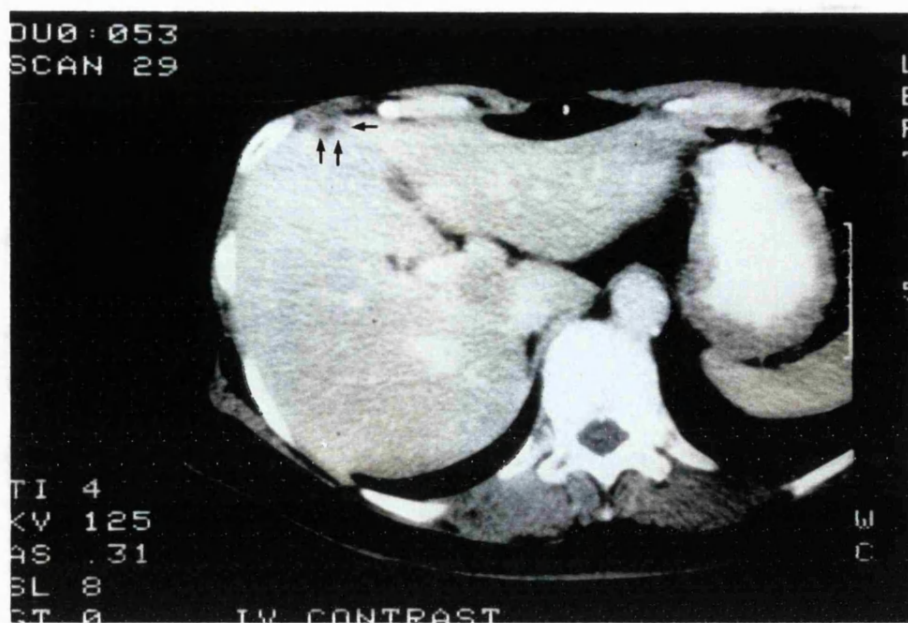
A contrast enhanced CT scan of a poorly enhancing 2 cm metastasis (arrowed) in the superficial portion of the right lobe.
